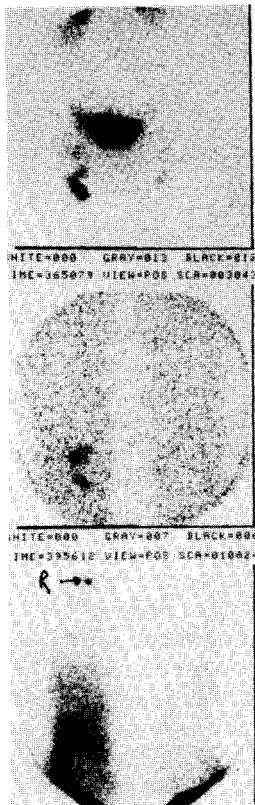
Lymphatic scintigraphy of primary lymphedema of legs before lymphatic-venous shunt. In the right leg, tracer activity is seen in the lower portion, less clear in the mid-thigh with nodal visualization in the groin. On the left neither lymphatics nor nodes are detectable.
